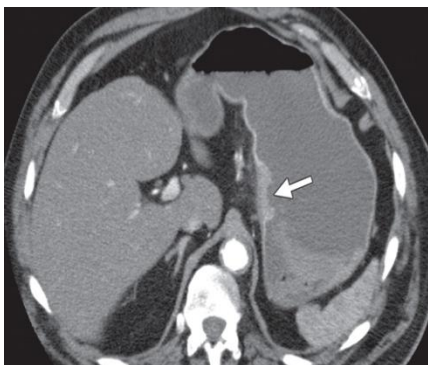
A 67-year-old man with a 4-day history of chest and epigastric pain. Axial computed tomographic (CT) image with intravenous contrast material shows focal, mild wall thickening with central ulceration (arrow) in the region of the gastric cardia.
